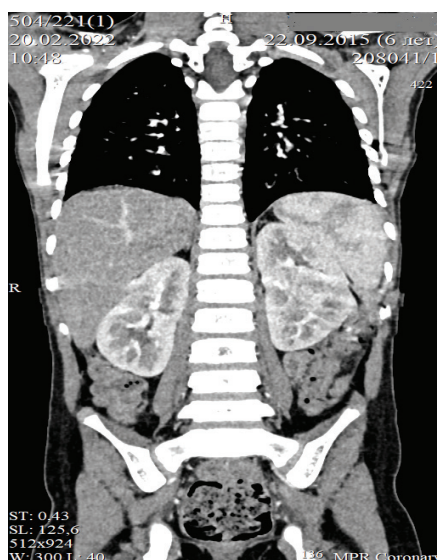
CT scan of the chest and abdomen. Abdominal cavity formation
